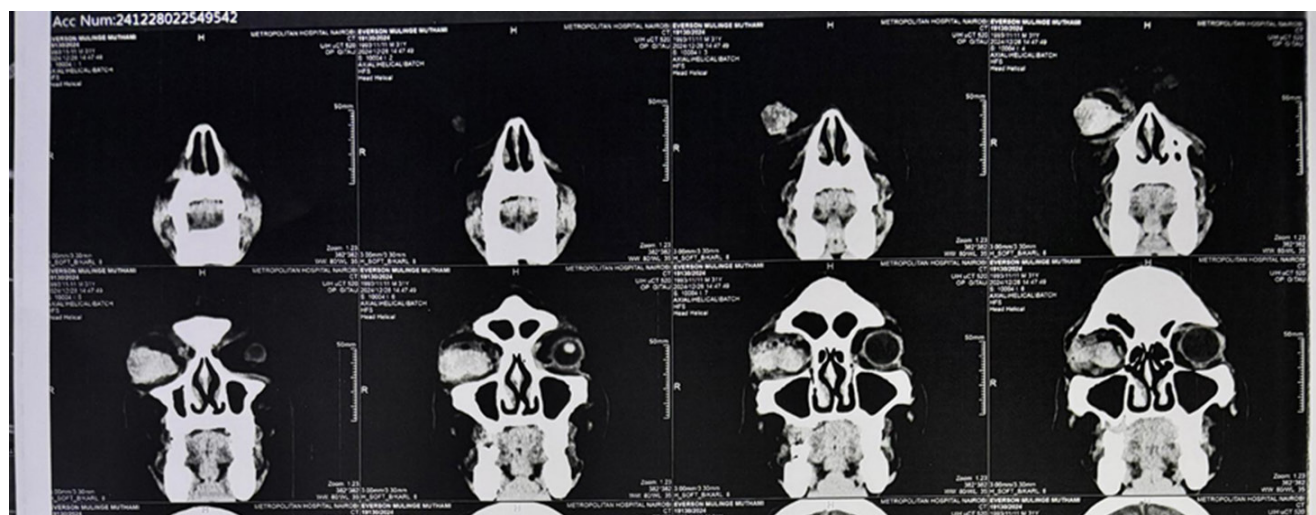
Coronal view of the CT scan. (@ Muyenzi Daryl)
